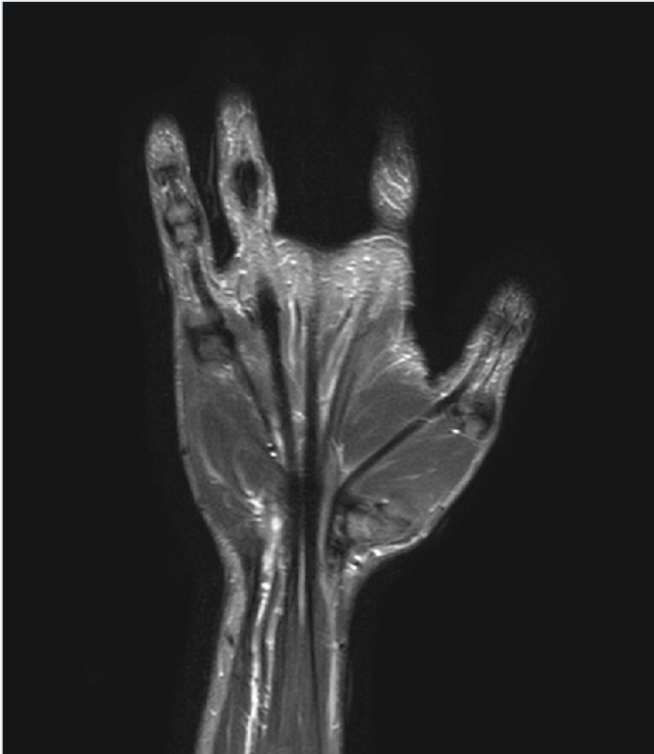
Contrast-enhanced magnetic resonance image after six months of surgery: no signs of local recurrence.
